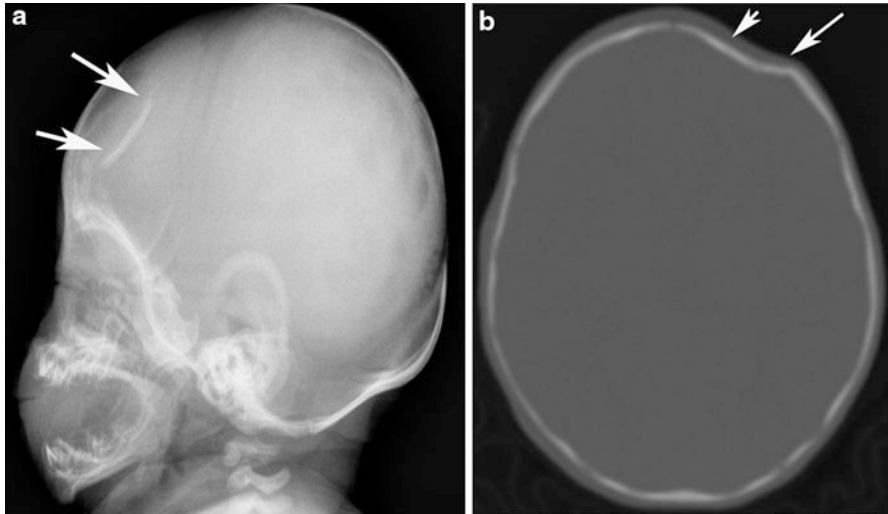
Lateral skull radiograph (a) and axial CT image in bone window (b) showing a depressed or ping-pong-type fracture in the left frontal bone (arrows)
